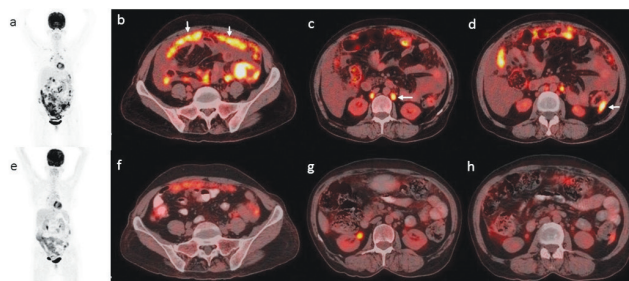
FDG PET/CT in a patient with metastatic ovarian serous adenocarcinoma; baseline maximum intensity projection (MIP) image (a) and fused axial PET/CT images show extensive intra-abdominal disease (a) with omental caking (b), retroperitoneal lymphadenopathy (c) and peritoneal deposits (d) with ascites (findings shown with white arrows). PET/CT done after 3 cycles of neoadjuvant chemotherapy shows decrease in disease burden, with significant reduction in metabolic activity of omental involvement (f), retroperitoneal lymph nodes (g) and peritoneal deposit (h) suggestive of partial response.
